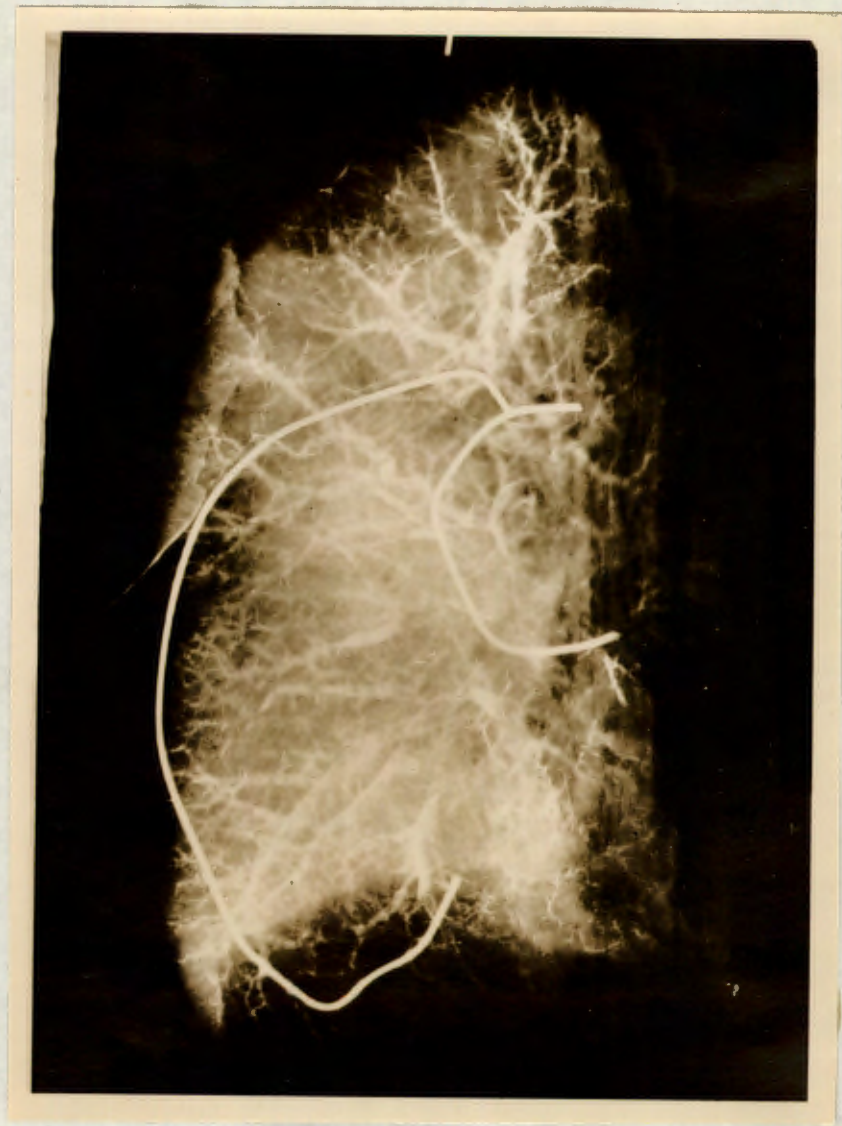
Postero-anterior radiograph of a right lung with the pulmonary vein injected with contrast material. The pieces of wire are in the oblique fissure.
